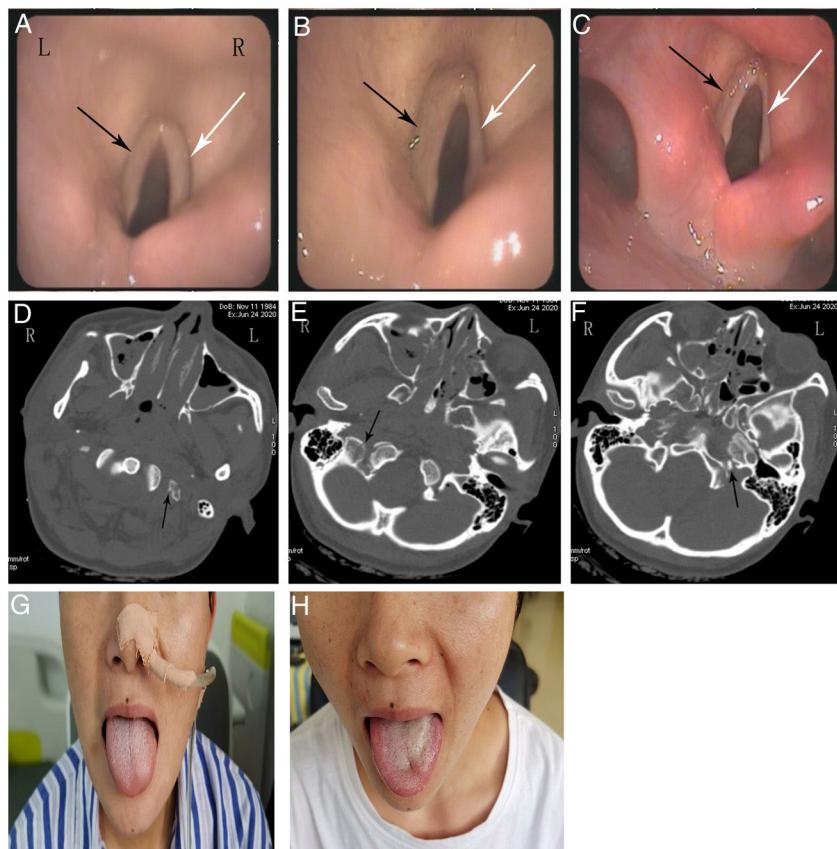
The electronic fiber laryngoscope shows that the bilateral vocal cords were fixed and the glottis could not move on July 23 (A). The left vocal cord (black arrow) was fixed and the right vocal cord (white arrow) was normal on August 21. There was a gap when the bilateral vocal cords closed (B). The left vocal cord (black arrow) was still fixed on September 21 (C). The computed tomography showed that the fracture of the left transverse process of the atlas and right skull base was mild (D, E). Bone fragments were found in the left occiput (F). The tongue tilted to the left on July 30 (G). The muscles of the left tongue were atrophy, and the tongue deviated to the left side on September 21 (H).
